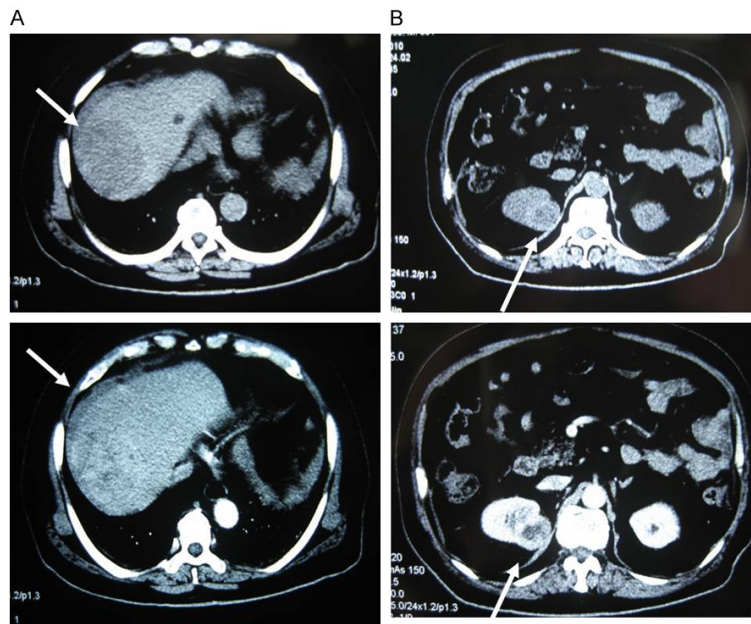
CT scans and contrast-enhanced CT findings. A low-density solid tumor is seen in the right hepatic lobe, and it shows a significant enhancement in isodensity (A. arrow) and a nonuniform enhancement of an irregular circular region in the right kidney (B. arrow).
